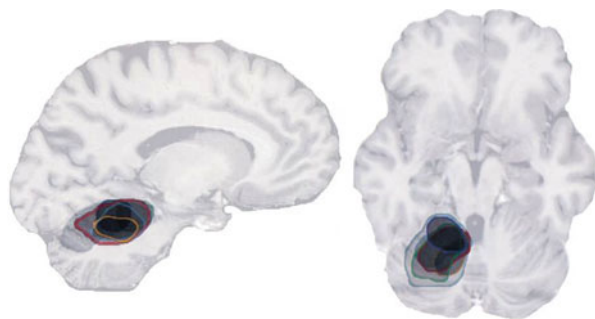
Superimposition of lesions in patients with the same disorder* (Reprinted from Urban et al. 2001, Fig. 2, with permission from Wolters Kluwer Health). Superimposed cerebellar ischemic lesions in six patients leading to dysarthria. Lesions are superimposed on sagittal and axial MRI scans of a healthy subject. Lesions are flipped to the same side
